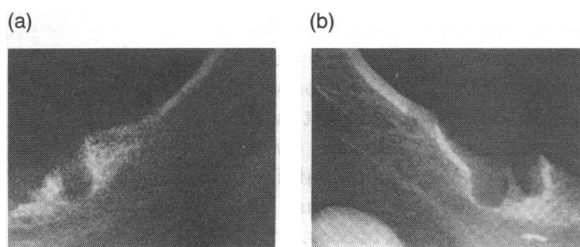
Radiograph of the mandible of the elder juvenile: (a) left molar region; (b) the right molar region
